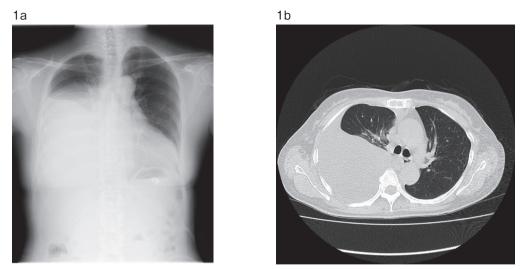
A plain chest X-ray showing massive right pleural effusion (a). Chest computed tomographic (CT) image showing massive right pleural effusion, atelectasis of the right middle and lower lobes, and mediastinal shift to the left (b).
